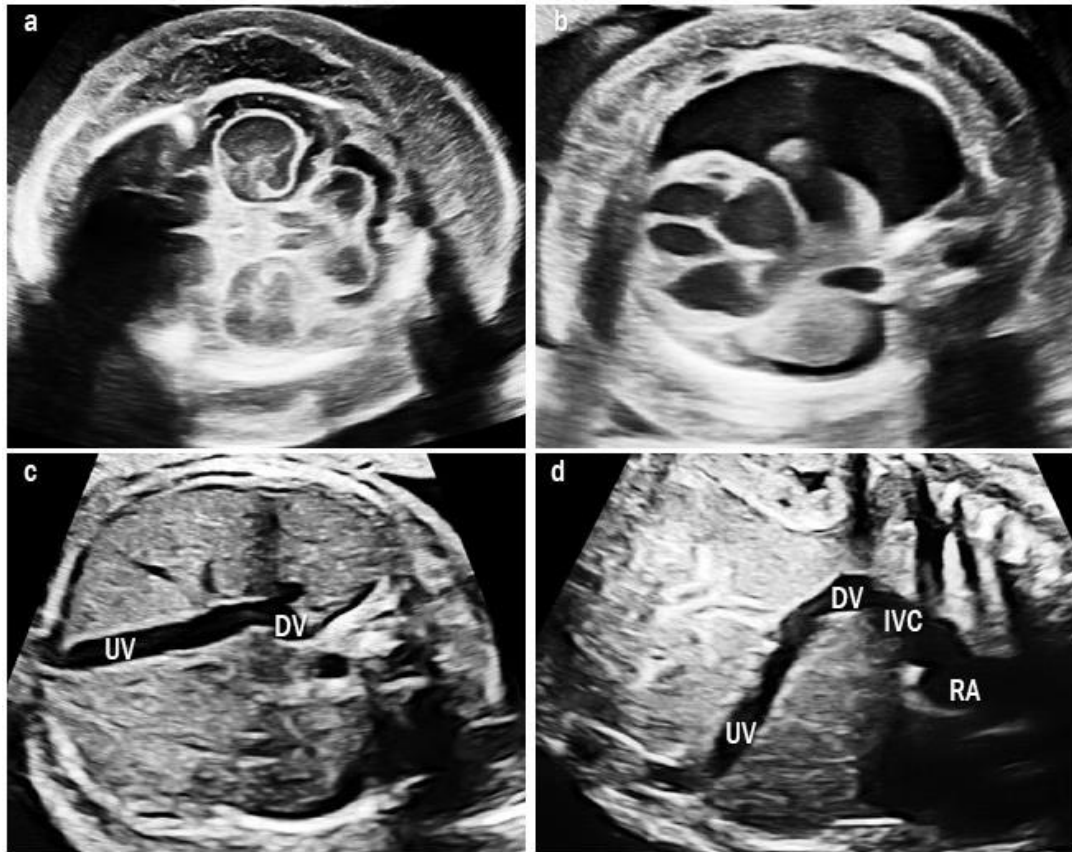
Ultrasound images of type II umbilical-portal-systemic venous shunt in case 9. The fetus showed severe fetal hydrops: (a) severe skin edema and (b) pleural effusion. (c) Transverse abdominal image shows the UV connected to the DV and it drains at the lower site than usual. (d) Sagittal image shows a short DV draining into the IVC below the diaphragm. UV, umbilical vein; DV, ductus venosus; IVC, inferior vena cava; RA, right atrium.
